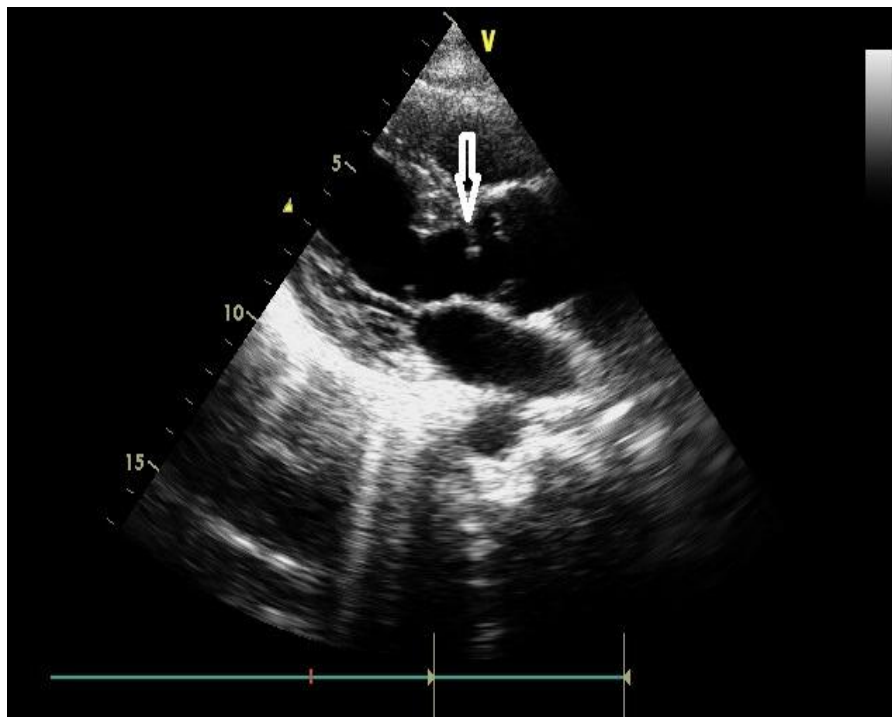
Echo – parasternal long axis view showing membrane just below the aortic valve
